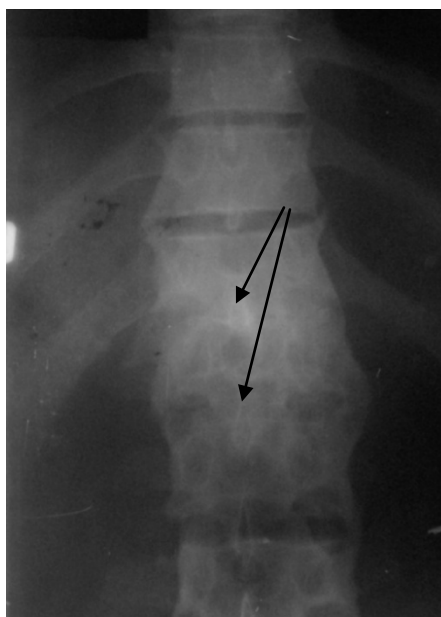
Radiograph of lumbar and chest departments of the backbone in a direct projection. The ankylosis Th12, L1 and L2 of vertebrae (arrows) is detected. Ankylosing tuberculous spondylitis of the backbone
